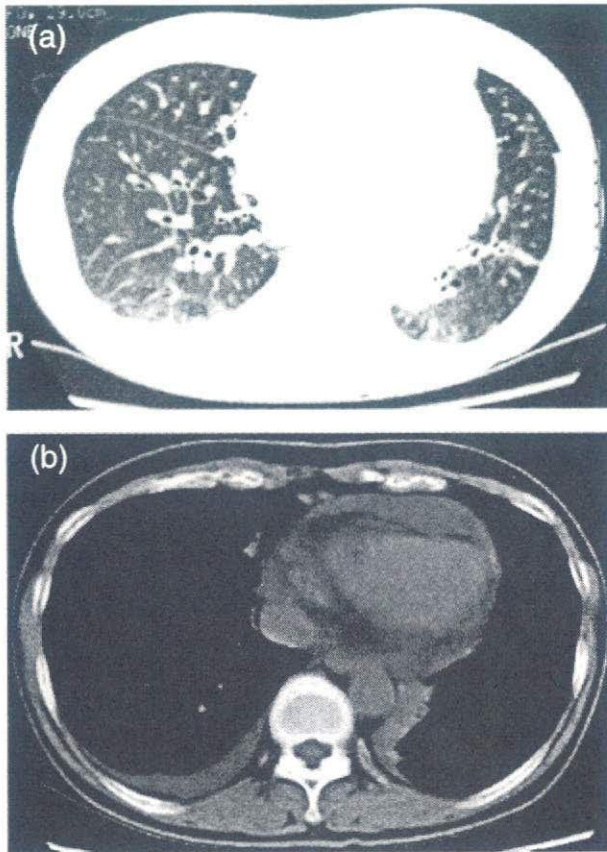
High-resolution CT scans at the time of onset of interstitial lung disease, demonstrating ground glass attenuation and interlobular septal thickening mainly in the lower lung fields (a), and pleuro-pericardial effusions (b).
